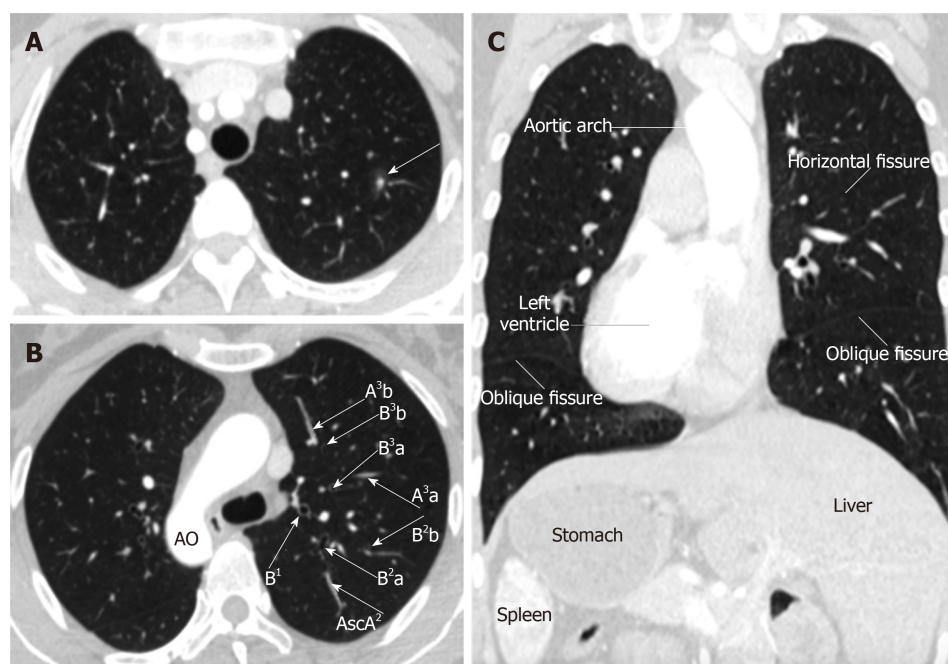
Computed tomography images. A: Mixed ground-glass opacity measuring 1.2 cm in diameter with a solid component of approximately 0.6 cm in the posterior segment of the left upper lobe (LS²); B: Complete mirror image of the segmental vessels and bronchus of LS²; C: Situs inversus totalis (dextrocardia, aortic arch, spleen, and liver). AsCA: Ascending artery.
